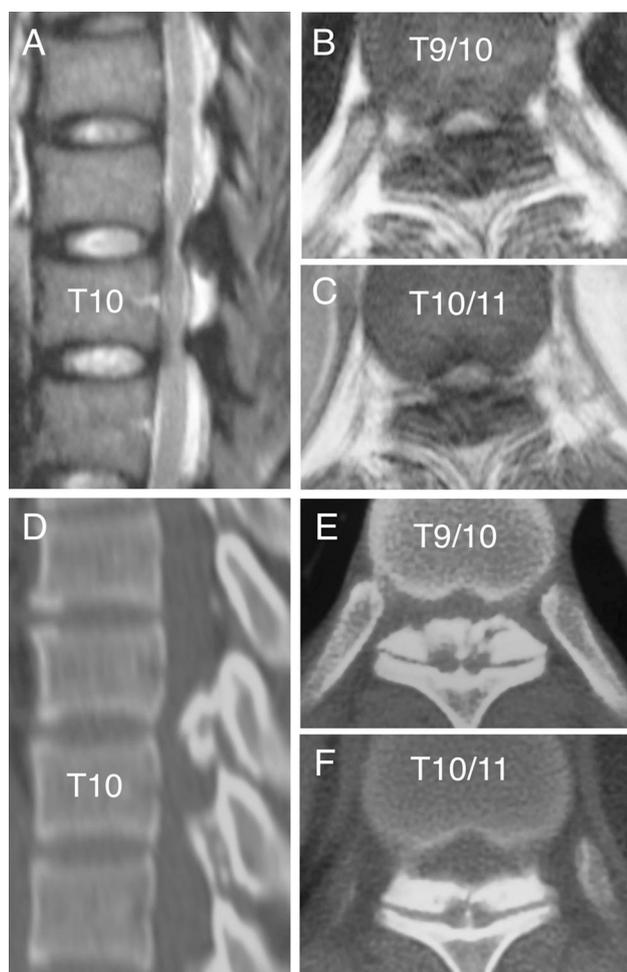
Case 1. MR images and CT scans obtained before the first operation. Sagittal (a) and axial (b, c) T2-weighted images show the compressed spinal cord at the T9–10 and T10–11 intervertebral levels. Sagittal reconstruction (d) and axial (e, f) CT scans show the OLF at the T9–10 and T10–11 levels
